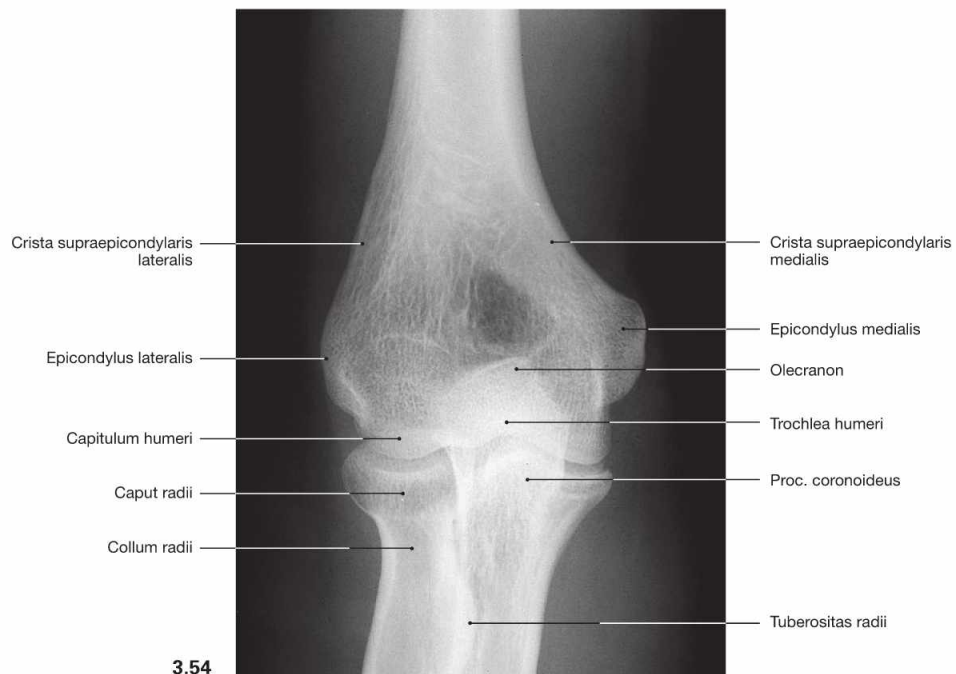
and Fig. 3.55 Elbow joint, Articulatio cubiti, right side; radiographs in anteroposterior (AP; → Fig. 3.54) and lateral (→ Fig. 3.55) beam projections.
